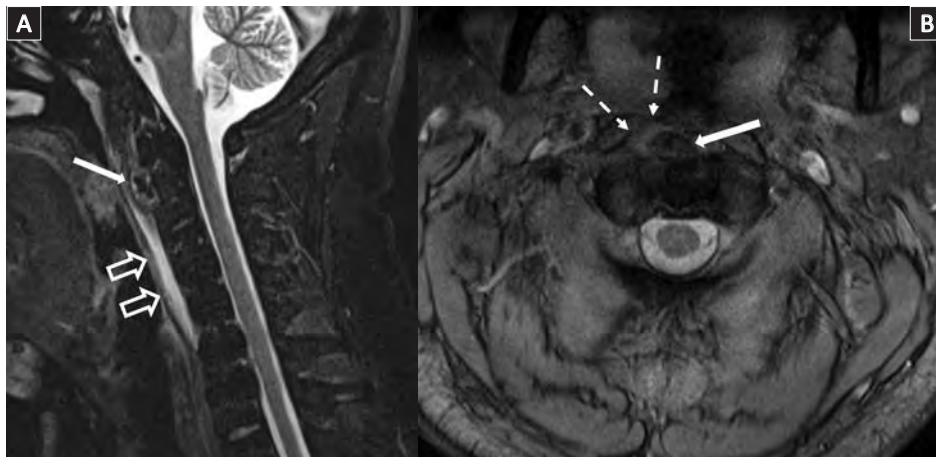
(A) Coronal T2W-STIR and (B) axial T2W-MEDIC magnetic resonance imaging of the cervical spine.
